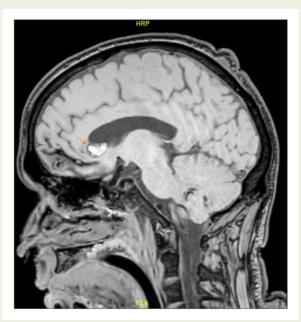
Magnetic resonance imaging head—T1 flair sagittal view shows there is a small intra-parenchyma subacute haemorrhage (red arrow) in the medial part of the left frontal lobe adjacent to the inferior margin of anterior horn of the left lateral ventricle with a haemorrhage measuring 17 mm.
